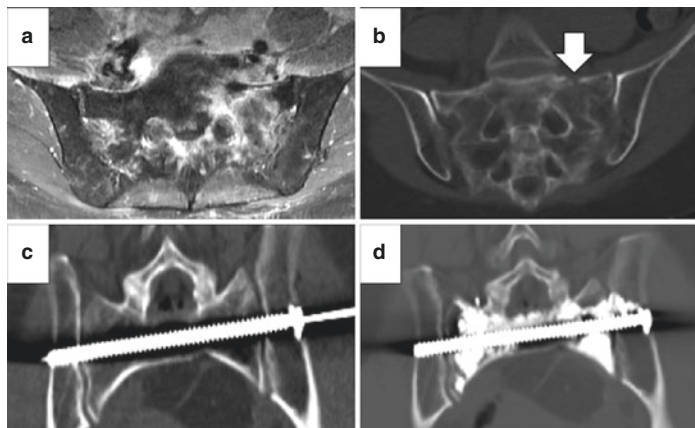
Painful, non-healing left sacral fracture from radiation-induced osteoporosis as a complication of colon cancer treatment ((a) MRI axial post-contrast with left sacral hyperintensity, (b) oblique axial CT image with cortical disruption, arrow), treated with fixation by internally cemented screw ((c) CT procedural oblique coronal image demonstrated cannulated screw advanced over a Kirschner wire, (d) CT procedural oblique coronal image after PMMA injection around the screw)
